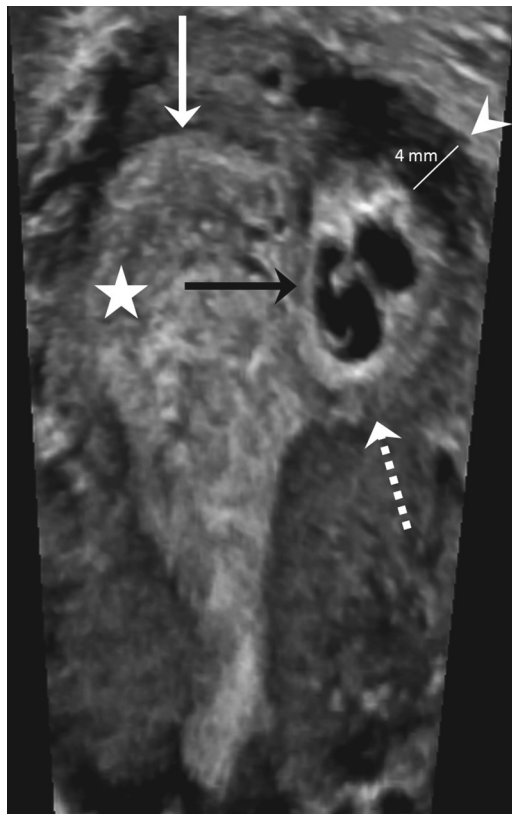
Three-dimensional ultrasound demonstrates a left-sided interstitial ectopic pregnancy (*black arrow*) with an eccentric gestational sac implanted within the interstitial portion of the fallopian tube (*dashed arrow*). The empty uterus (*white arrow*) and the thin myometrial layer overlying the interstitial pregnancy (*arrowhead*) are visualized. The *star* represents the hypothetical eccentric location of an uncommon mimic, an angular pregnancy, located in the far lateral uterine fundus near the tubal ostium completely surrounded by endometrium.
